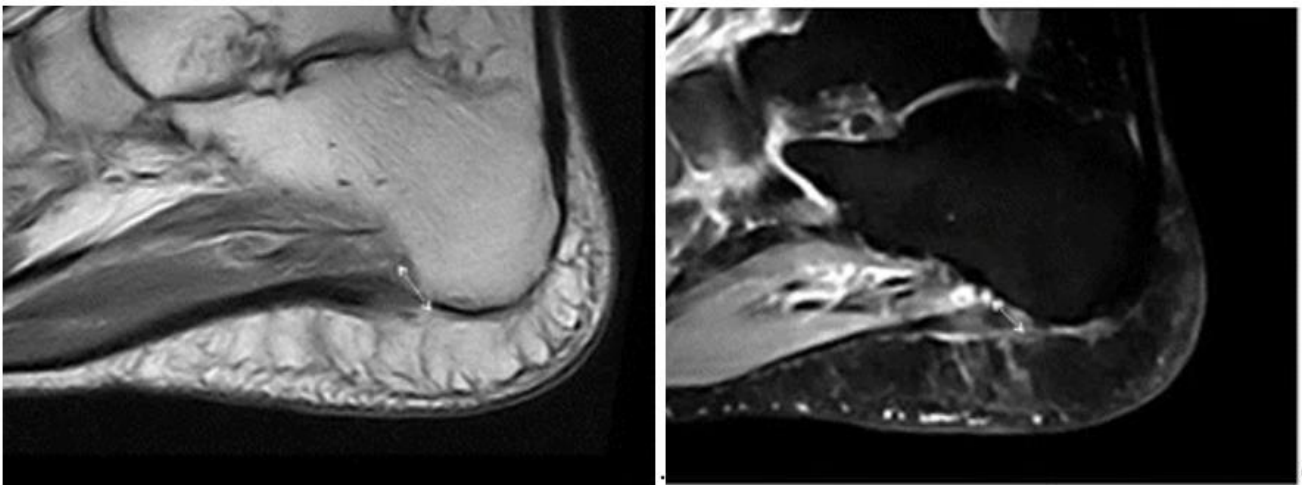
MRI: T1 Weighted image and fluid sensitive image showing thickened plantar fascia and signal changes at the calcaneal origin.
